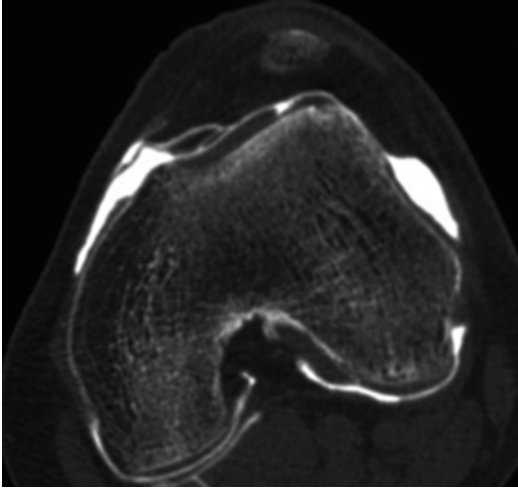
Arthro-CT allows analysis of PF joint articular cartilage
